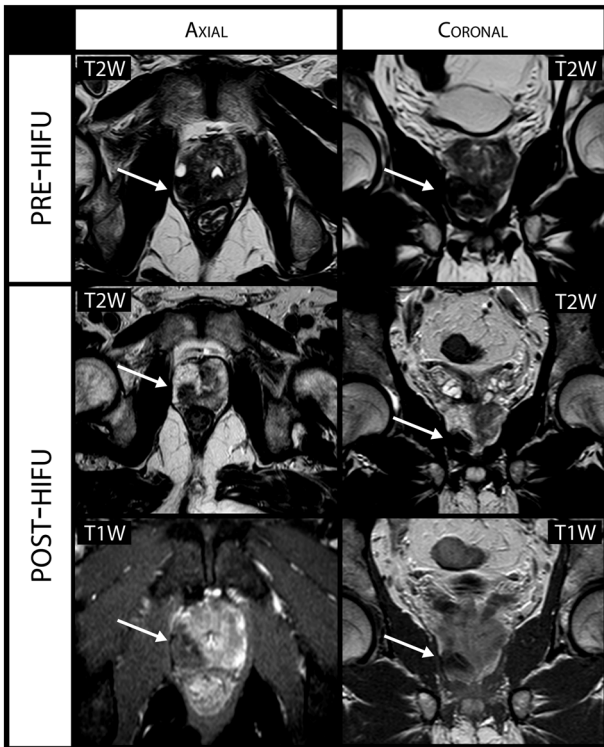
Multiparametric MRI images (T2-weighted [T2W] and T1-weighted [T1W]) showing 1-year tumor recurrence after HIFU right lobe hemiablation for a right posterior tumor. Transurethral resection of the prostate was performed before the ablation.
